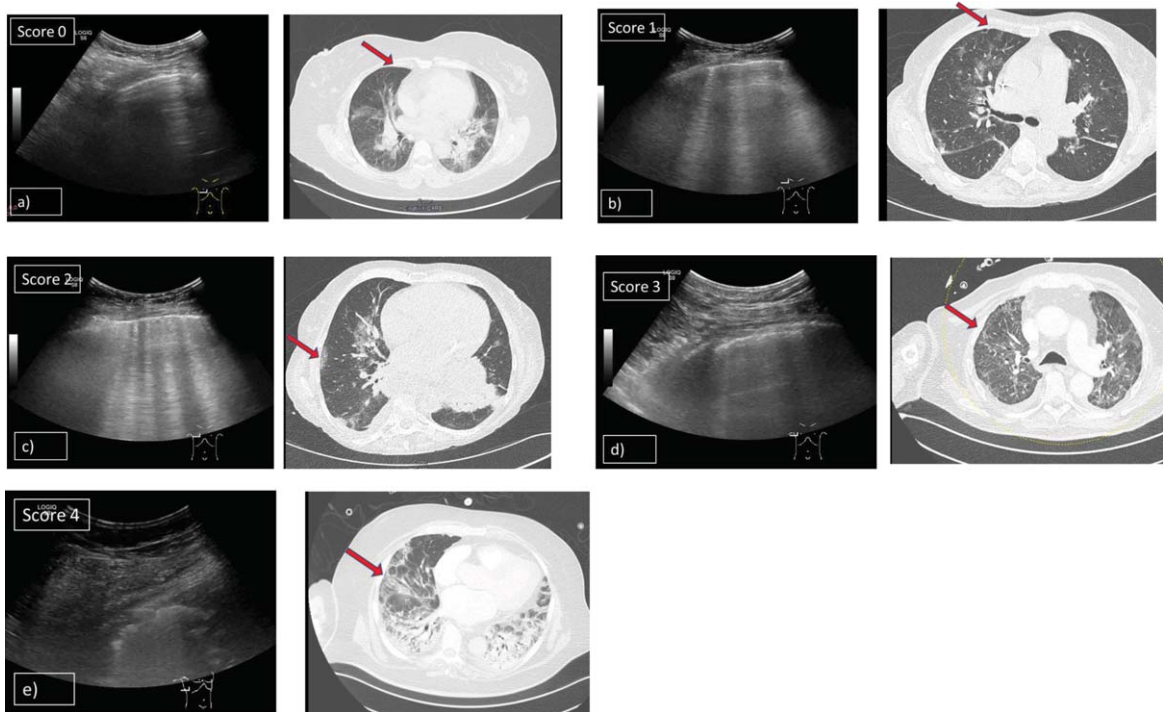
Grading system of lung opacities used for the lung aeration score in patients with ARDS and COVID-19 pneumonia. Shows findings of LUS in patients with COVID-19 pneumonia and corresponding HRCT scans. 5 levels of typical opacities of the lung could be observed and were graded in a scoring system from minimum 0 points to maximum 4 points. a) Score 0: A-lines detected by ultrasound B-mode using a 1–5 MHz convex probe and corresponding HRCT scan (CT was done 3 days before LUS). b) Score 1: More than 2 ( $\geq 3$ ) single B-lines detected by ultrasound B-mode using a 1–5 MHz convex probe and corresponding HRCT scan (CT was done 3 days before LUS). c) Score 2: Multiple, coalescent B-lines detected by ultrasound B-mode using a 1–5 MHz convex probe and corresponding HRCT scan (CT was done 4 days before LUS). d) Score 3: Marked pleural disruptions detected by ultrasound B-mode using a 1–5 MHz convex probe and corresponding HRCT scan (CT was done at the same day as LUS). e) Score 4: Severe consolidations with air bronchogram sign detected by ultrasound B-mode using a 1–5 MHz convex probe and corresponding HRCT scan (CT was done at the same day as LUS).
